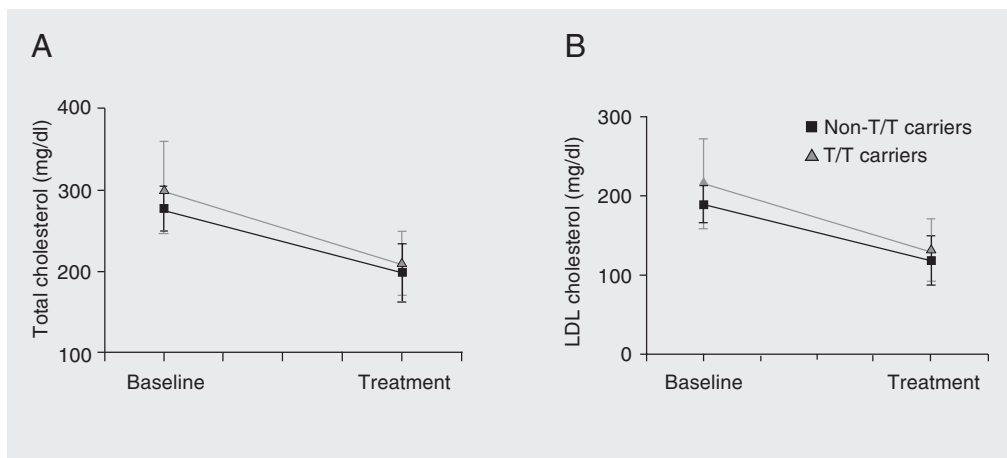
Serum concentration of total (A) and low-density lipoprotein (LDL) cholesterol (B) in Brazilian hypercholesterolemic individuals of European descent according to *MDR1* haplotype, before (baseline) and after atorvastatin therapy (10 mg/day). Non-T/T carriers: GG/CC, GG/CT, GG/TT, GT/CC, GA/CC haplotypes; T/T carriers: GT/CT, GT/TT, TT/CT, TT/TT, TA/CT haplotypes. Repeated measures ANOVA: $P > 0.05$ for differences between non-TT and TT carriers.
